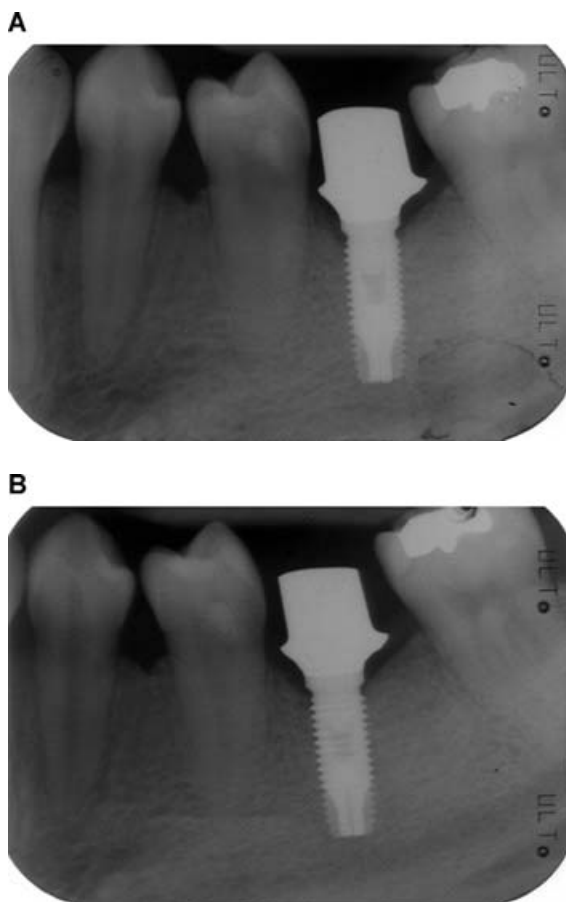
(A) Radiograph of titanium abutment at the time of abutment insertion. (B) Radiograph of titanium abutment 4 years after abutment placement.
